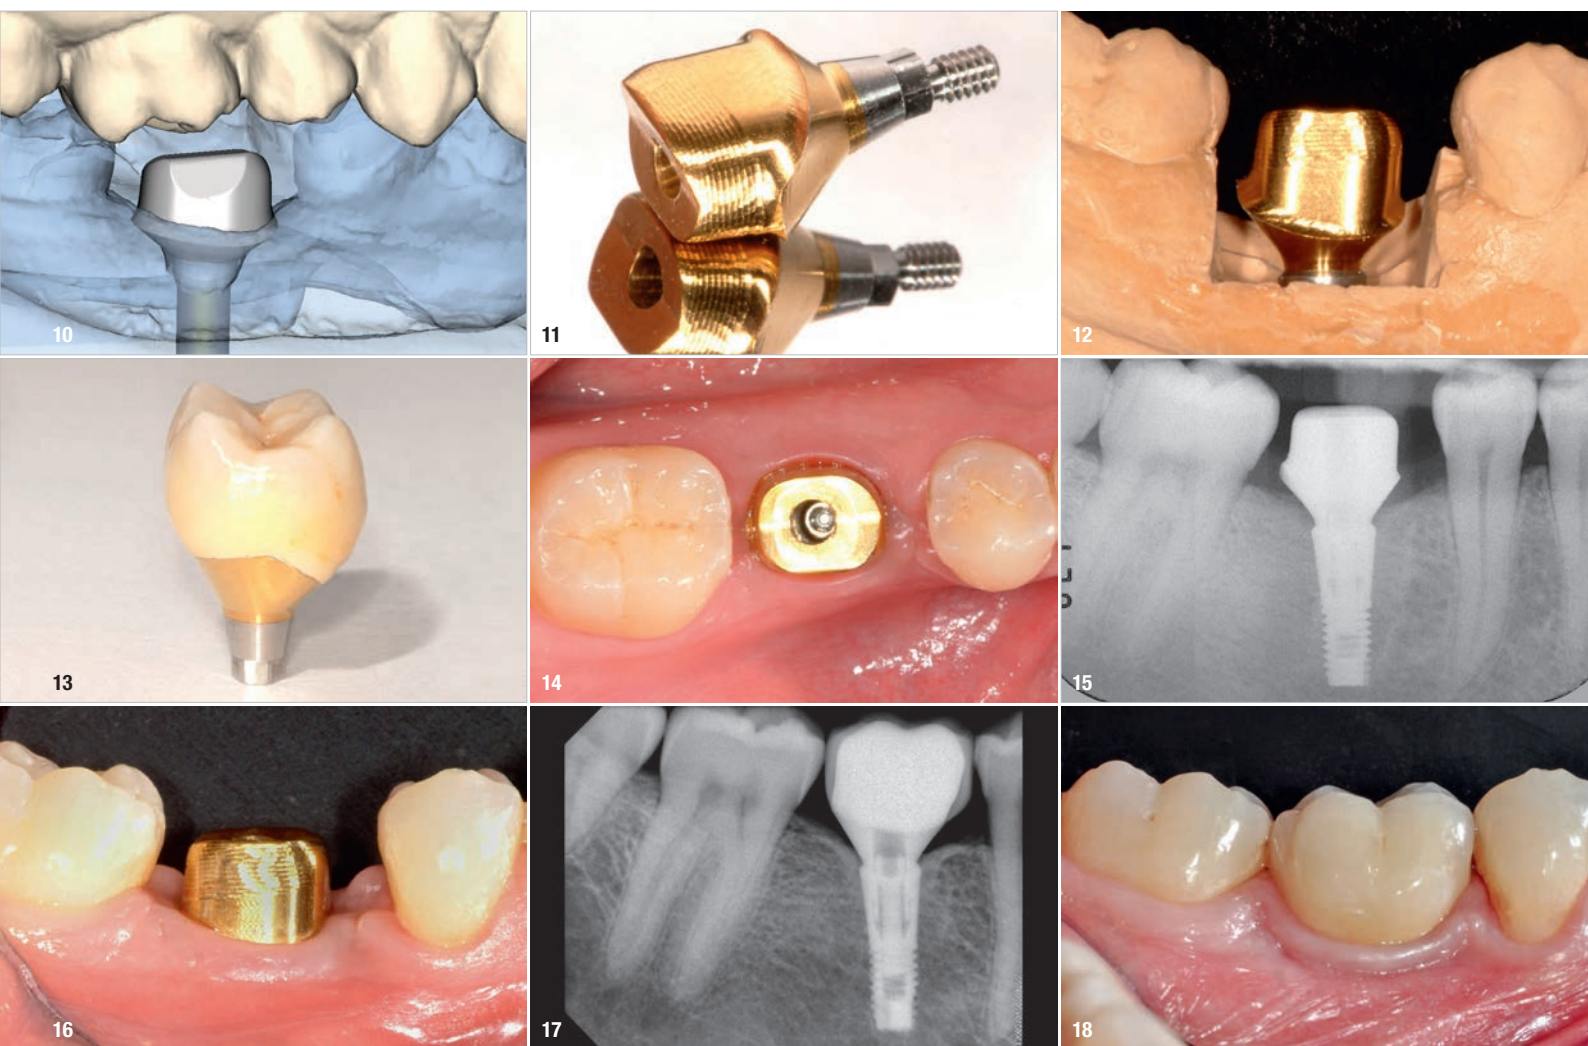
After eight weeks of healing, the soft tissue over the extraction area was completely healed. Fig. 5: After eight weeks, the amount of bone formation into the socket allowed for implant placement. Fig. 6: Using a surgical stent, the osteotomy could be performed in an adequate position in 3D, using the zenith of the cervical contour of the planned restoration as a reference point. Fig. 7: The implant was placed 3 mm apical to the cervical contour of the planned restoration, symmetrically from the mesial to distal aspect, and 2 mm to the lingual aspect in order to preserve the buccal bone that would support the soft tissue. Fig. 8: A 7 mm healing abutment was placed to guide the soft tissue to an optimal healing situation. Fig. 9: The healing abutment was removed after six weeks, and a final impression of the implant position and the shape of the soft tissue was sent, together with the opposing model, to the dental laboratory. Fig. 10: The Atlantis abutment was virtually designed with the emergence width of the replaced molar and manufactured in titanium with a titanium nitride coating. Fig. 11: The Atlantis abutment in gold-shaded titanium, together with the Atlantis abutment screw, was sent to the dental laboratory. Fig. 12: The subgingival portion of the abutment would give the anatomical shape, support and colour to the surrounding soft tissue. The definitive crown restoration in zirconia was fabricated. Fig. 13: Definitive implant restoration with the finishing line close to the gingival margin, allowing for easy removal of excess cement in the subgingival area. The restoration was ready to be delivered to the patient. Fig. 14: The Atlantis abutment was placed with some pressure on the soft tissue. After a few minutes, the ischaemia disappeared, and the abutment was seated in the correct position. Fig. 15: Verification of correct seating of the abutment using a radiographic image. Note that the transitional portion of the abutment followed the contour of the bone. Fig. 16: The Atlantis abutment in gold-shaded titanium was torqued to the implant manufacturer's recommendation of 25 Ncm. The screw head was covered, and the crown was later cemented to the abutment. Fig. 17: After ten years, the radiograph showed a perfect fit of the restoration, the spaces created for the interproximal papillae and the position of the bone at the level of the implant. Fig. 18: After ten years, a perfect adjustment of soft tissue around the restoration (buccal view) was observed, filling the space for the interproximal papillae and yielding a natural-looking soft-tissue contour.
